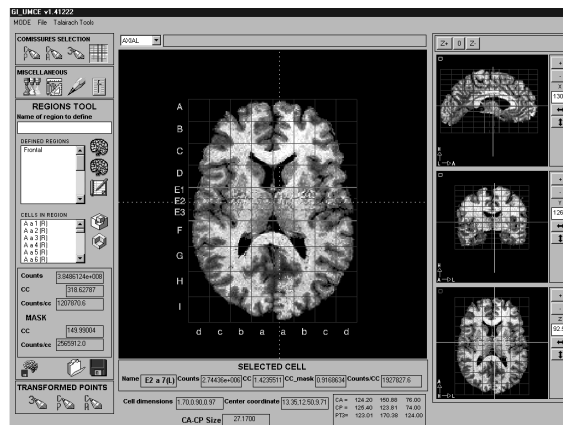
A screenshot of the software tool developed for volumetric and functional quantification of brain images. The triplanar view shows a Talairach grid built upon an MRI and a co-registered PET superimposed for quantification. For each of the 1,065 cells of the grid, volume and metabolic data is obtained for each brain tissue (total or WM, GM, CSF separately).
